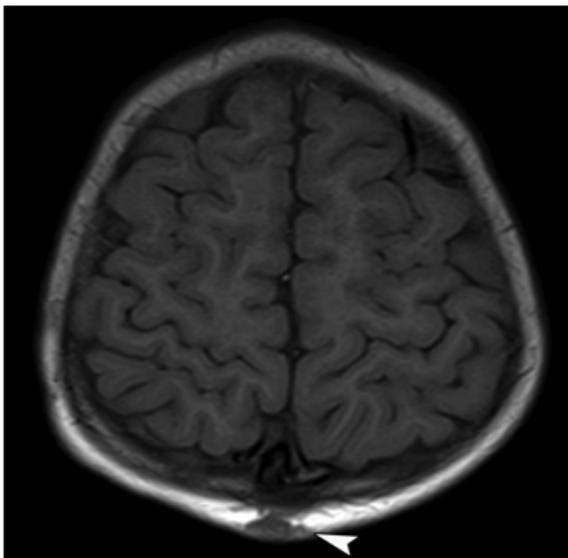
Axial T1 weighted MRI without contrast demonstrating a 15 x 6 x 11 mm midline subcutaneous soft tissue lesion (indicated by white arrowhead).
